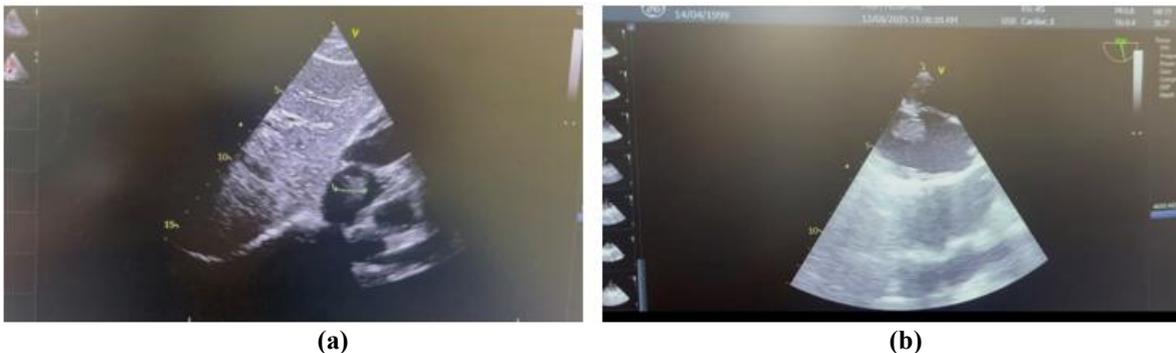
Preoperative transthoracic echocardiography. (A) Subcostal view demonstrating the right atrial mass with measurement calipers. (B) Modified apical view showing the echogenic mass within the right atrium near the IVC–hepatic vein junction.
